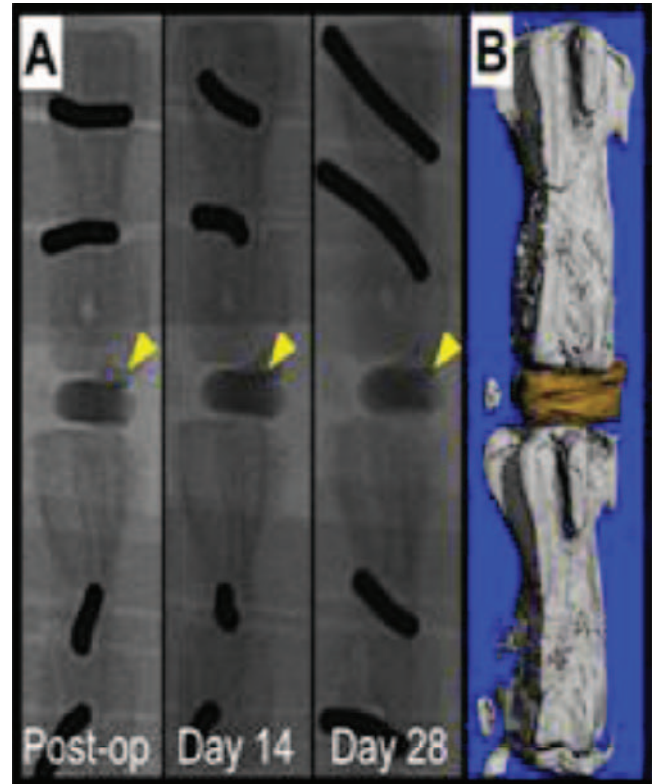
Implantation of high radiodensity rDAPS. A) Fluoroscopy over 28 days. B) μ CT reconstruction after 28 days.
